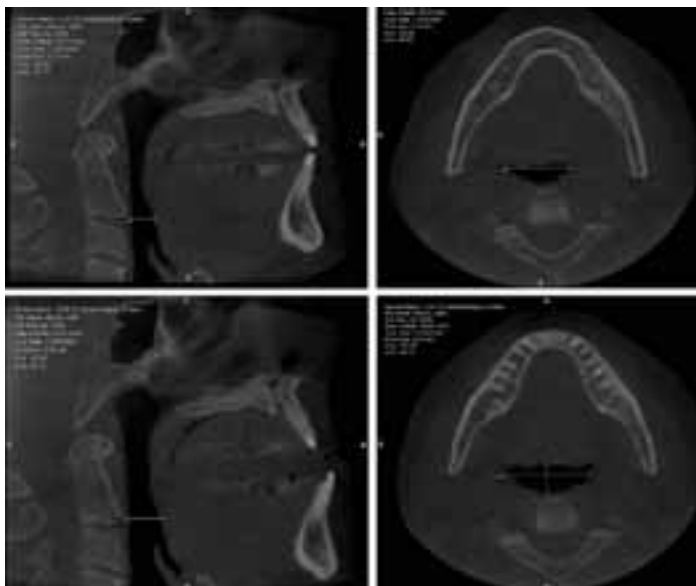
CONE BEAM TOMOGRAMS. TOP TWO IMAGES SHOW THE PATIENT AT REST POSITION, TONGUE IN ROOF OF MOUTH AND NO APPLIANCE. BOTTOM IMAGES ARE TAKEN WITH APPLIANCE IN PLACE, TONGUE IN ROOF OF MOUTH, LIPS SEALED. MARKED IMPROVEMENT IS DEMONSTRATED IN AIRWAY DIMENSIONS WITH APPLIANCE IN PLACE.
